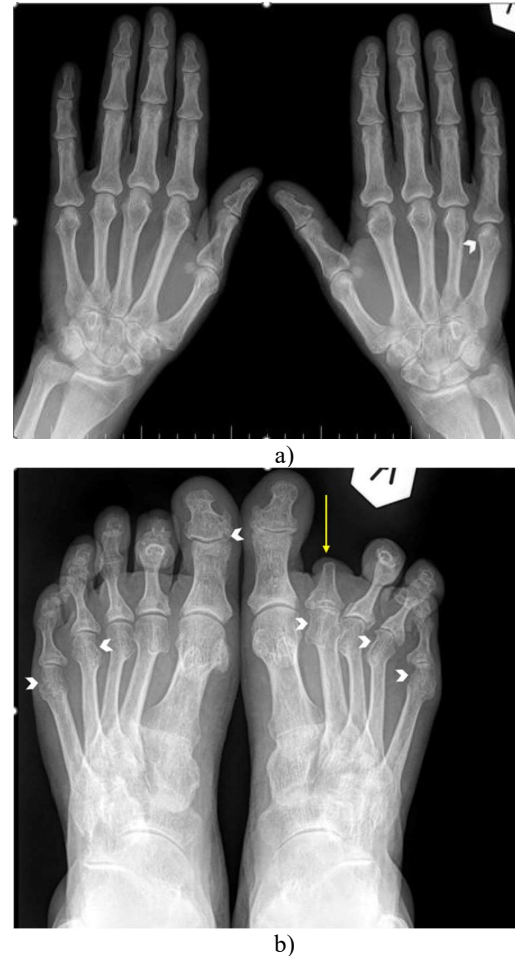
a) Bilateral hand X-ray (AP view): linear erosion at the level of the 5th metacarpophalangeal joint of the right hand (arrow head) b) Feet x-ray (AP view): large, symmetric erosions at the level of 5th, 4th, 2nd metatarsophalangeal joints of the right foot and at the level of the 1st interphalangeal joint and the 4th and 5th metatarsophalangeal joints of the left foot (arrow head), joint space narrowing, diffuse demineralisation and amputation of the second toe of the right foot secondary to hammer toe changes (yellow arrow).
